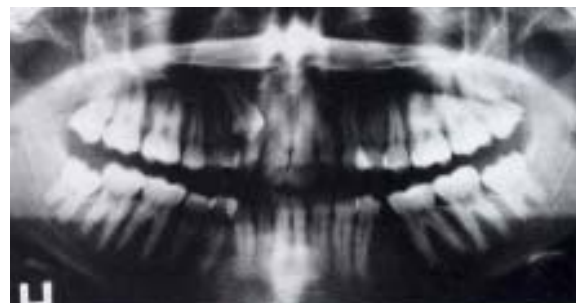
Pre-treatment OPG radiograph.
